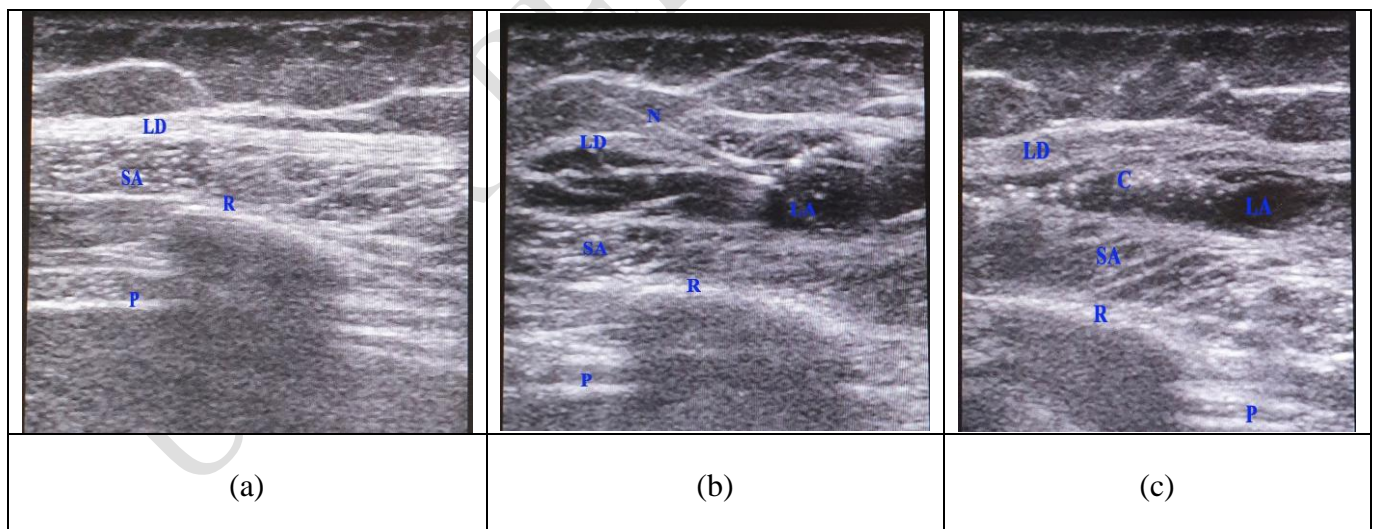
a) Ultrasound view of serratus anterior muscle and latissimus dorsi muscle, b) Local anesthetic injection between serratus anterior and latissimus dorsi muscle, c) Catheter inserted through the needle after injection of loading dose of local anesthetic. SA; serratus anterior, LD; latissimus dorsi, R; rib, P; pleura, N; needle, LA; local anesthetic, C; catheter.
